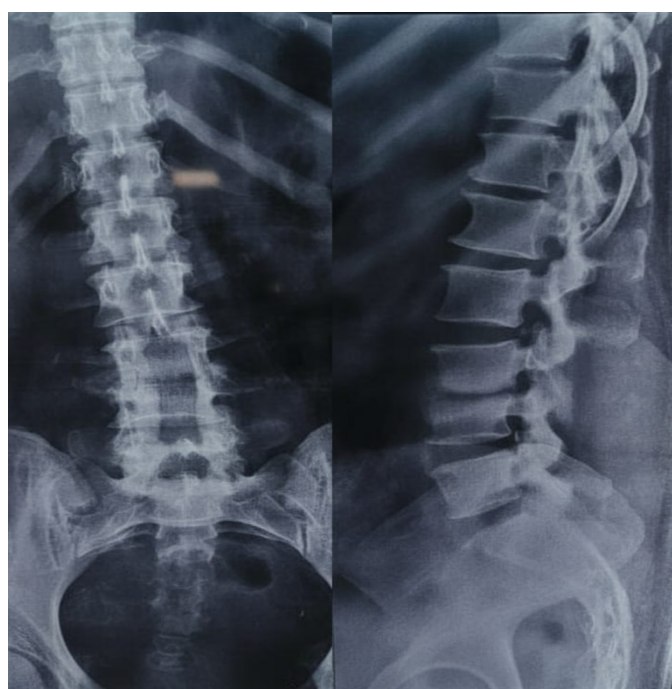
Xray at 5 months
